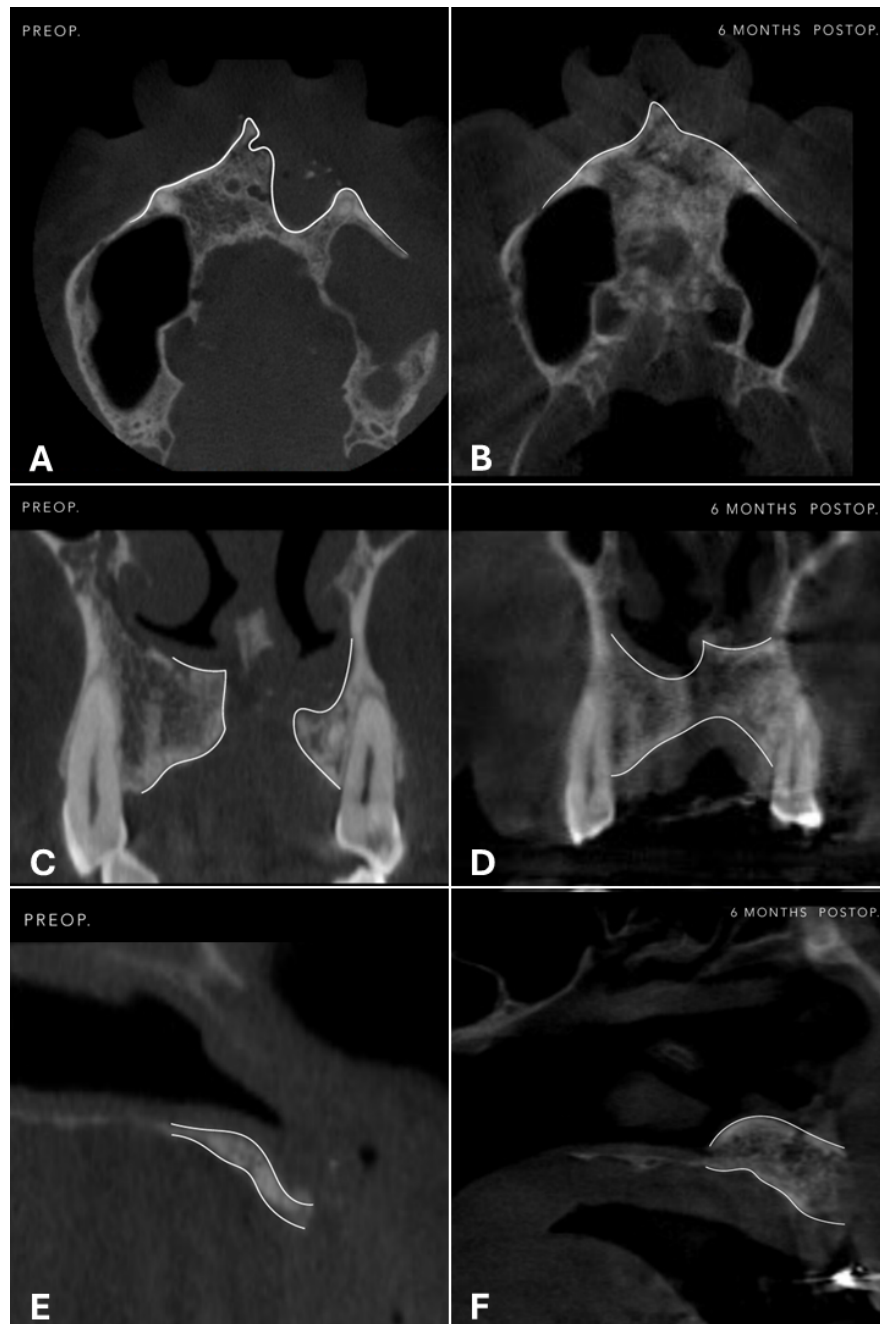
(A) Axial preoperative cone-beam computed tomography showing total bone loss at the affected site, directly related to the oronasal communication. (B) Axial tomography at 6 months follow-up, showing significant bone regeneration in both height and width of the alveolar bone and proper reconstruction of the nasal floor. (C) Sagittal preoperative cone-beam computed tomography showing total bone loss at the affected site, directly related to the oronasal communication. (D) Sagittal tomography at 6 months follow-up, showing significant bone regeneration in both height and width of the alveolar bone and proper reconstruction of the nasal floor. (E) Coronal preoperative cone-beam computed tomography showing total bone loss at the affected site, directly related to the oronasal communication. (F) Coronal tomography at 6 months follow-up, showing significant bone regeneration in both height and width of the alveolar bone and proper reconstruction of the nasal floor.
